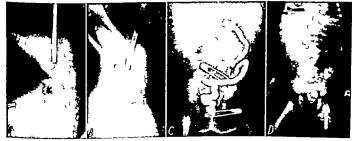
Case 5. The findings in (a) reproduced from a roentgenogram made to minutes after the infant was subpreded head down, show evidence superstive of high rectal imperioration. This was disproved by insuffaction of air (b)
